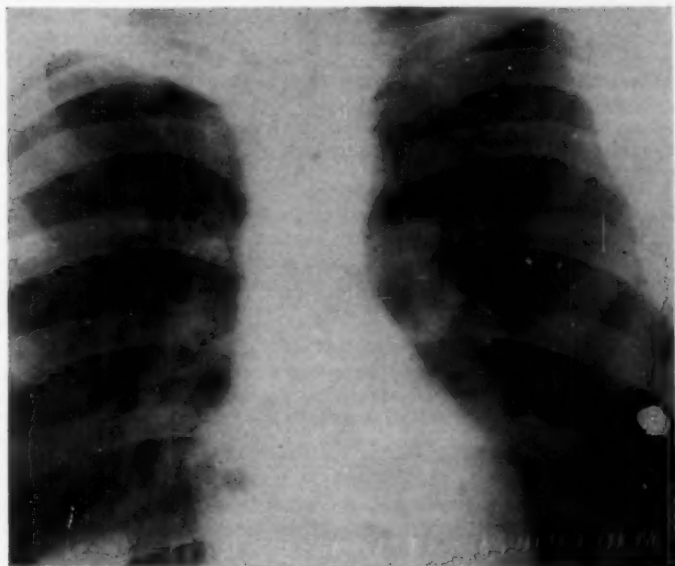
(Case 5, J. Y.): Roentgenogram reveals circumscribed density above right leaf of diaphragm. Courtesy, Dr. B. M. Fried.
